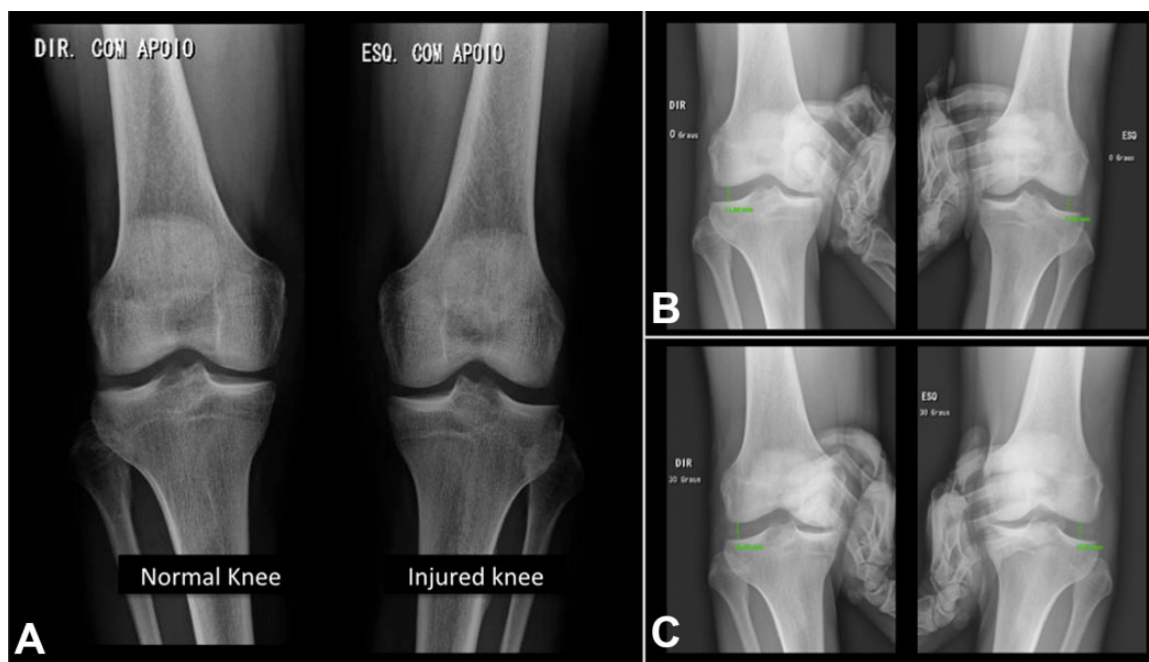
Radiographic images comparing the normal (right) and injured (left) sides: (A) anteroposterior (AP) view; (B) AP stress view, 0° of flexion; (C) AP stress view, 30° of flexion.
